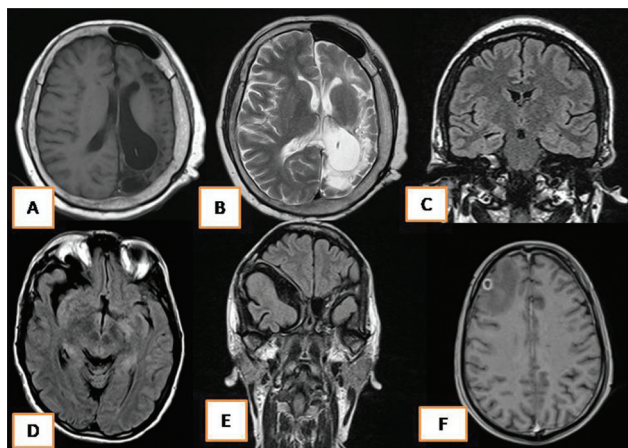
(A, B) Magnetic resonance imaging (MRI) brain axial fluid-attenuated inversion recovery (FLAIR) and T2-weighted imaging showing diffuse atrophy of the left cerebral hemisphere with periventricular cystic encephalomalacia and ex-vacuo dilatation of left lateral ventricle. Enlargement of the left frontal sinus, and mastoid antrum with ipsilateral calvarial thickening. (C) Coronal FLAIR showing hyperintensities in right hippo campus with mild atrophy. (D, E) MRI brain axial and coronal FLAIR showing right sphenoid wing hypoplasia, dilated cerebrospinal fluid spaces in middle cranial fossa, and anterior displacement of right temporal lobe. (F) MRI brain axial T1-weighted imaging postcontrast study showing a well-defined ring enhancing lesion in right frontal lobe.
